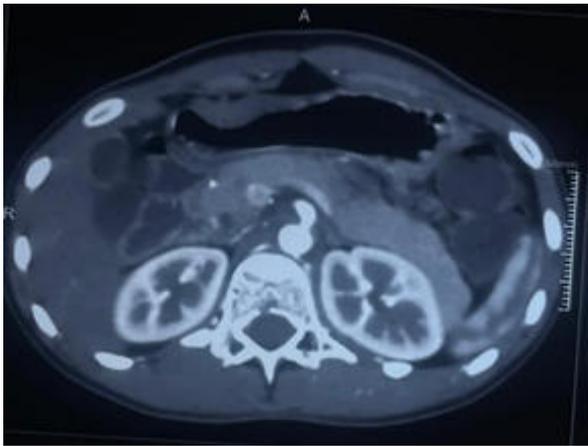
CT Angiogram image showing focal narrowing of proximal celiac artery
